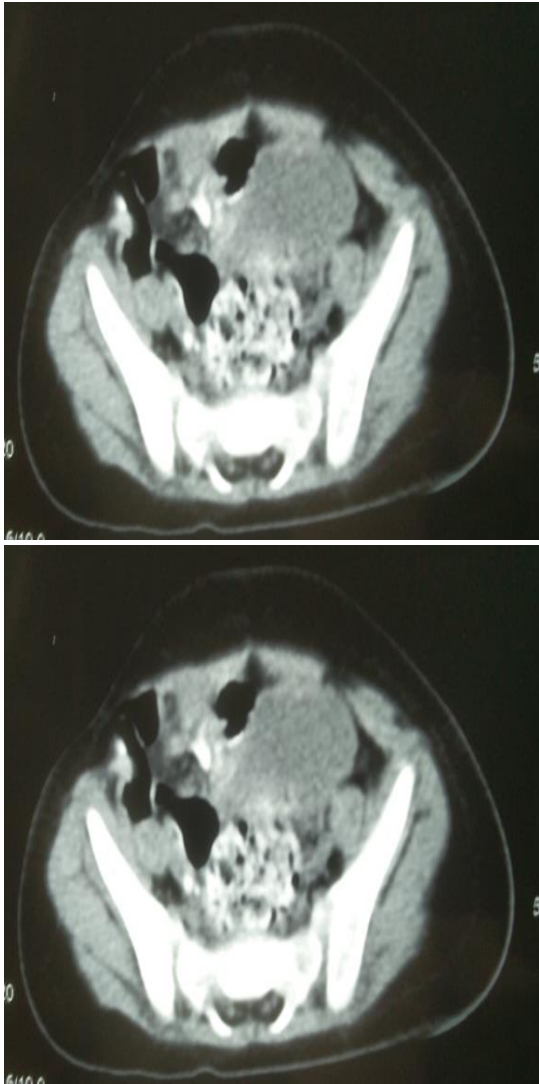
CT images showing herniation of bowel loops and preperitoneal fat through the defect lateral to linea semilunaris
